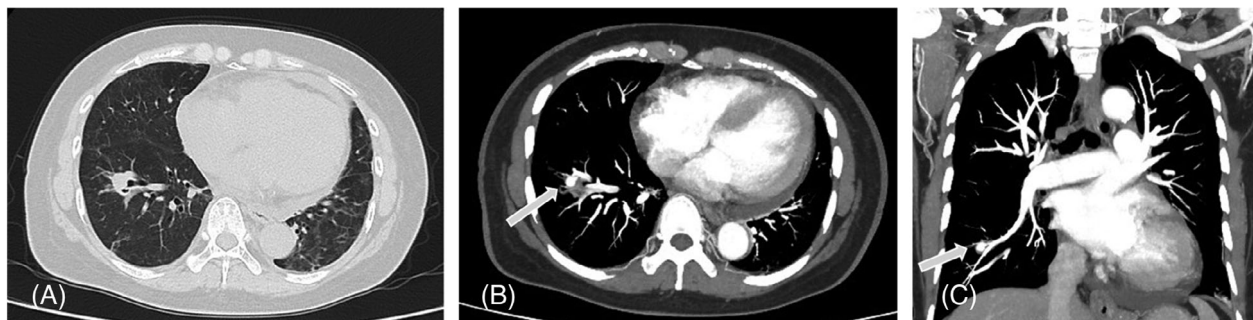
(A) Computed tomography lung window shows nodule in the right lower lung with reticular infiltration of both lungs. (B) Computed tomography angiogram (CTA) in axial view shows 1.3×2.3 cm pseudoaneurysm of anterior basal segment of the right lower lobe subsegmental pulmonary artery (arrow). (C) CTA in coronal view.
